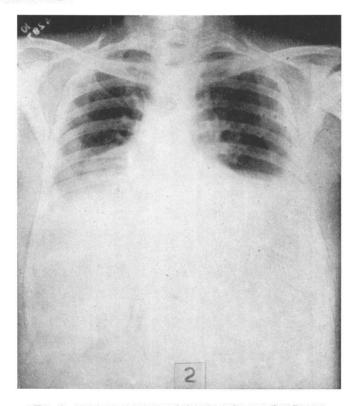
A roentgenogram of the chest from a "wet" case.
